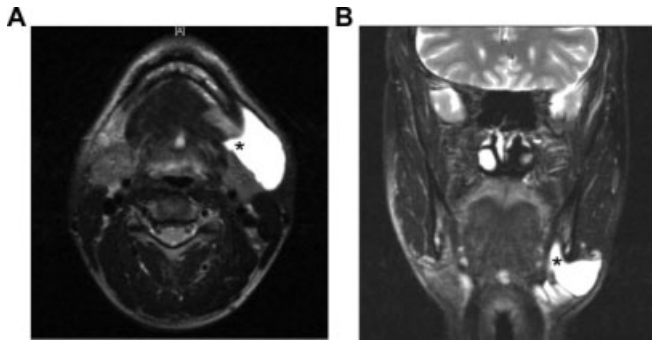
(A) Axial view magnetic resonance imaging (MRI) (T2-weighted) of patient 11, showing the high intensity mass (*) in the left oral floor. T1-weighted MRI shown in low intensity. (B) Coronal view MRI (T2-weighted) of patient 6, demonstrating the high-intensity mass (*) in the oral floor and typical tail sign, which showed SLG origin of plunging ranula.
